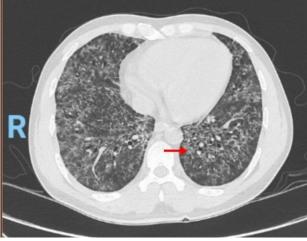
Thorax contrast computed tomography (CT) showed interstitial lung disease (arrow sign)
